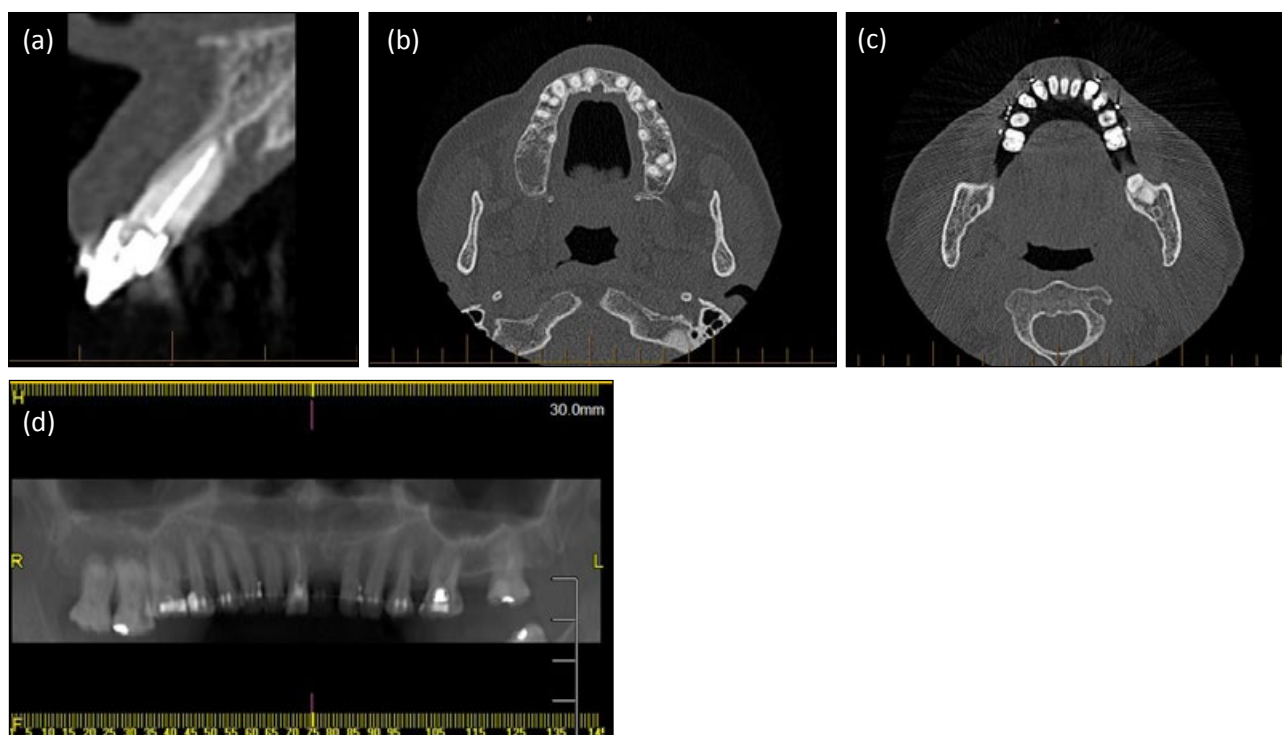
Pre-implant 3D CT scan. (a) Satisfactory angulation of the 11 within the alveolar ridge. (b) Upper teeth remain within the anatomical limits of the alveolar bone. (c) Lower teeth remain within the anatomical limits of the alveolar bone. (d) Reconstructed panoramic film reveals appropriate root parallelism for the planned restorative implant in the 21 edentulous space.
